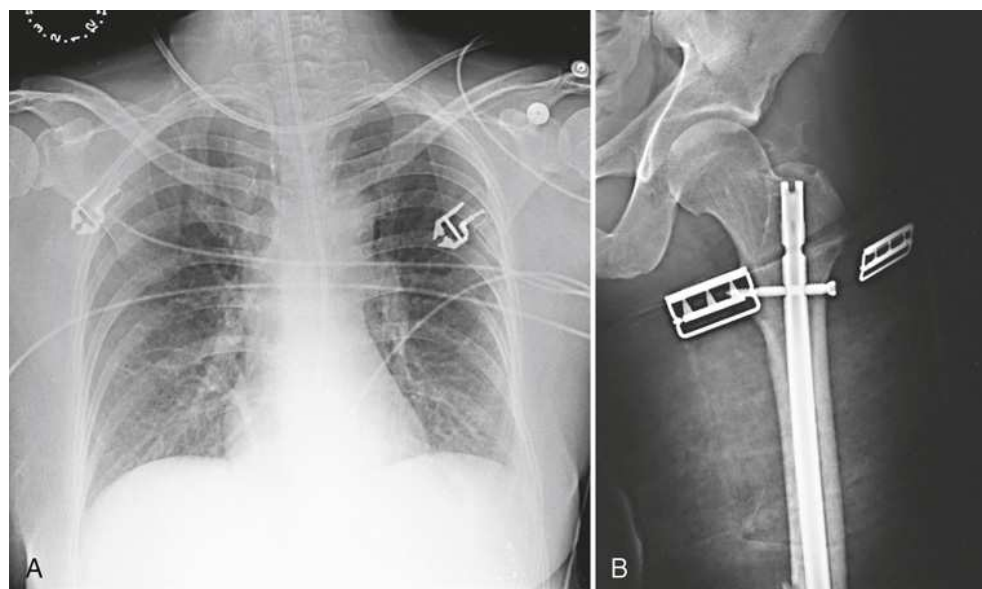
(A) Mobile radiograph of chest. Note various objects in the image that could not be removed for the exposure. (B) Mobile radiograph of proximal femur and hip. Metal buckles could not be removed for the exposure.
